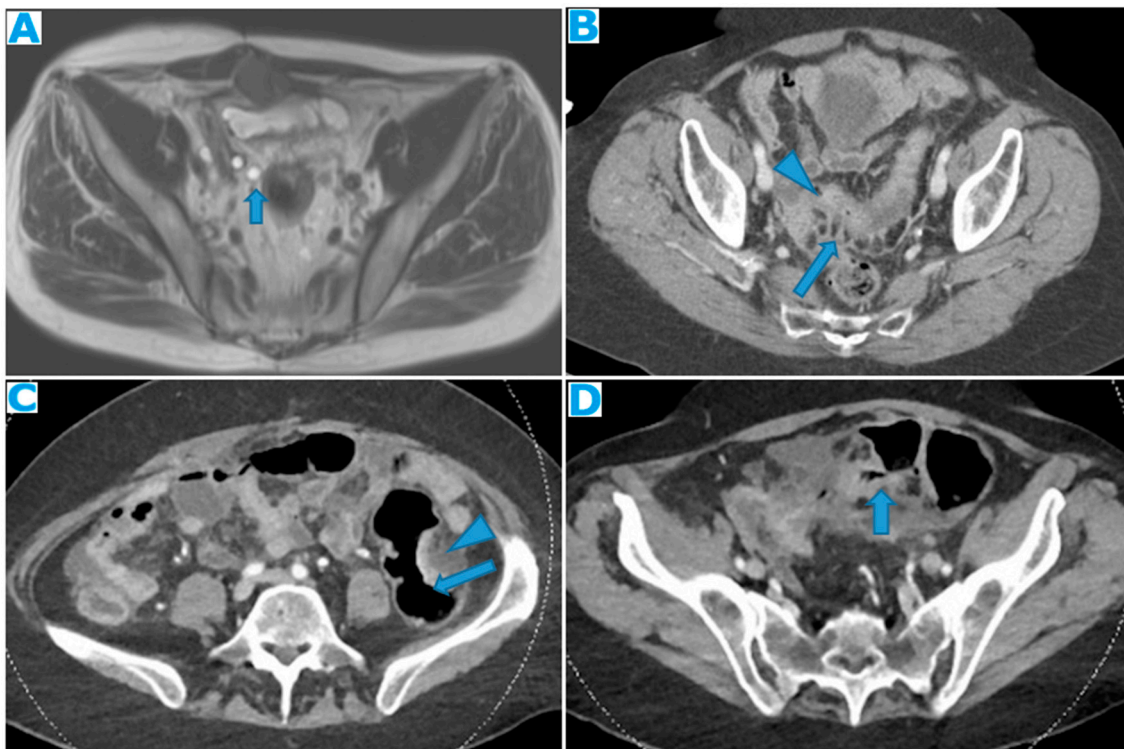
Axial T2WI (A). PC from mucinous adenocarcinoma of the terminal ileum: Hyperintense nodular deposits (due to mucin-content) within the sigmoid mesocolon. Axial CE-CT (B). PC from undifferentiated carcinoma of unknown origin: Deposits within both the sigmoid mesocolon (arrows), outlining the epiploic appendices, and within the sigmoid serosa, making the sigmoid colon appear thickened (arrowheads). Axial CE-CT (C, D). PC from colon adenocarcinoma: A. Observe on C the seeding involving the sigmoid mesocolon (arrowhead) and the serous layer of the bowel
